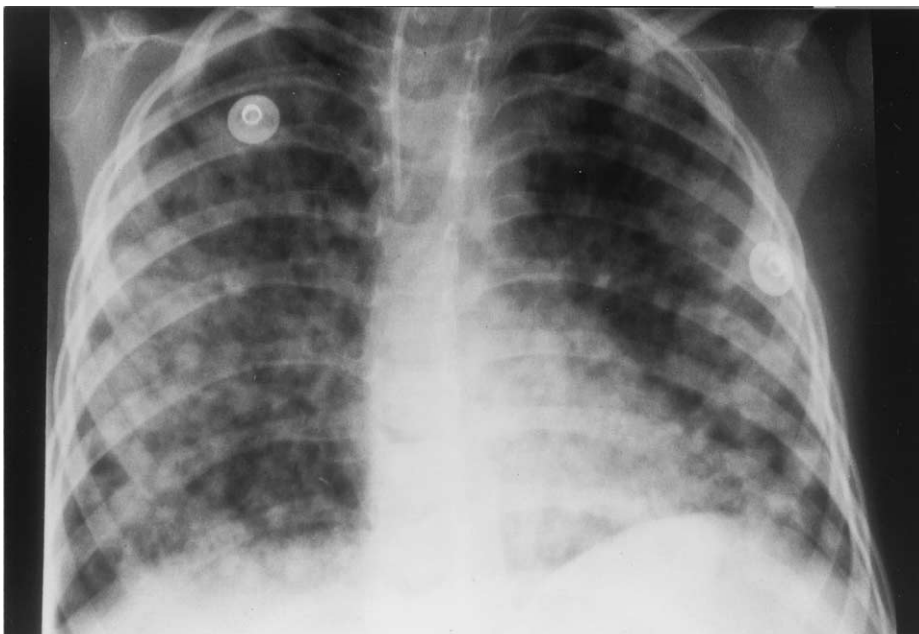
Anteroposterior chest x-ray on day 25 depicts bilateral nodular infiltrates as characteristic indications of acute respiratory distress syndrome.
